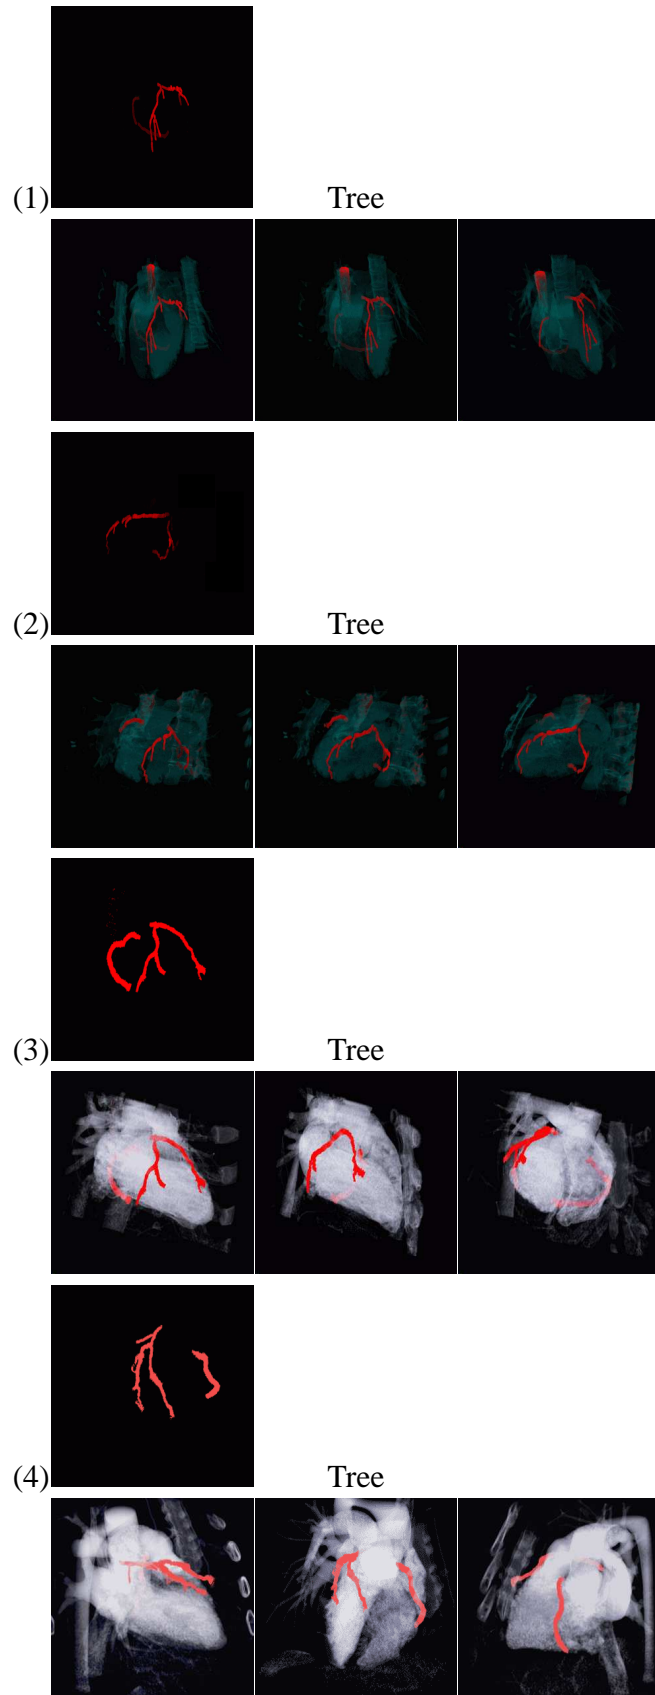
Segmentation of the Left anterior descending coronary artery and Right coronary artery in CTA (in red) for four patients (1) & (2) & (3) & (4); Different 3D views super-imposed to the cardiac volume are presented.
